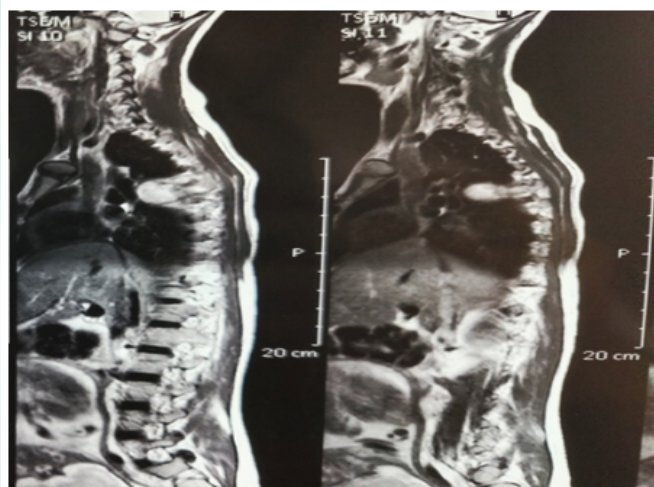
MR imaging of the whole spine in the sagittal section reveals Infective spondylodiscitis at D4-D5 vertebrae with right paravertebral soft tissue.
